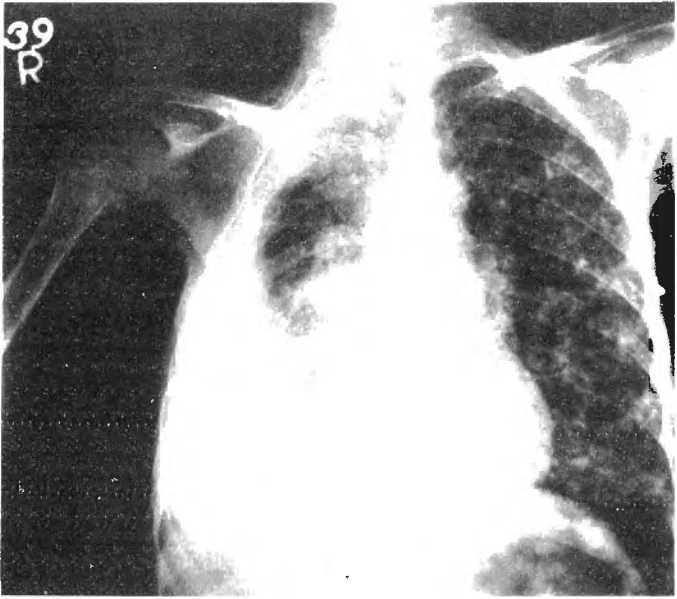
Second chest x-ray of same female patient showing widespread bone and lung metastases after one year.
